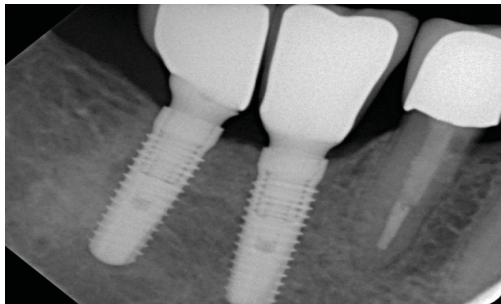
Exemplary single-tooth radiograph of a PS restoration 24 months after prosthetic loading. There is no bone loss to be seen.
